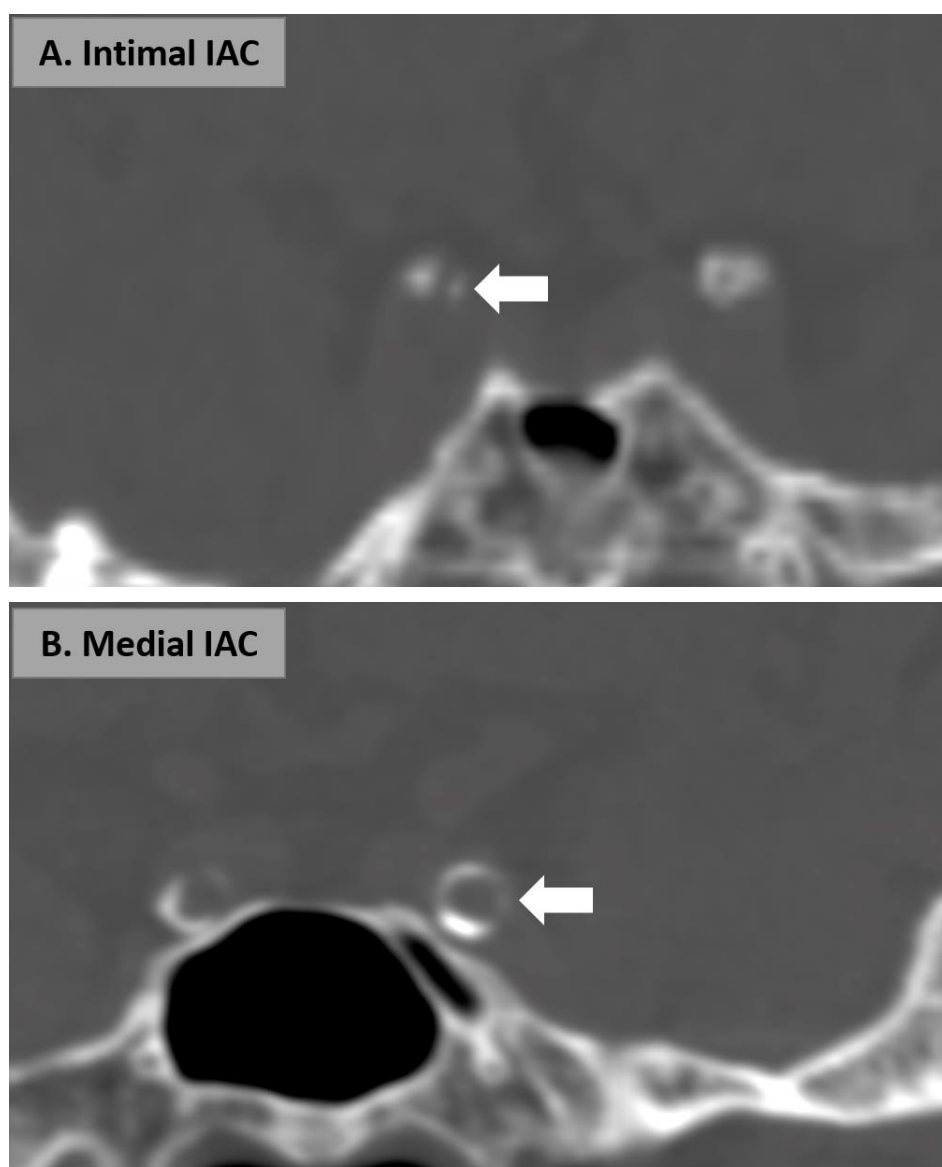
Intracranial arterial calcification (IAC) patterns on brain computed tomography (CT) images: intimal IAC (A) and medial IAC (B).
